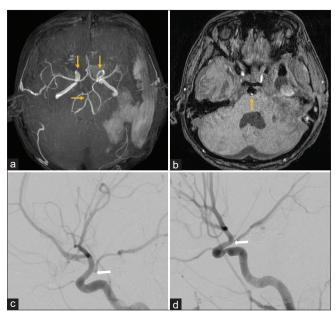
Head magnetic resonance imaging on day 42 showed no obvious blood flow in the aneurysm and the basilar artery stenosis and bilateral internal carotid artery stenosis had improved (a and b; orange arrow). Digital subtraction angiography also revealed improved bilateral internal carotid artery stenosis (c and d; white arrow).
